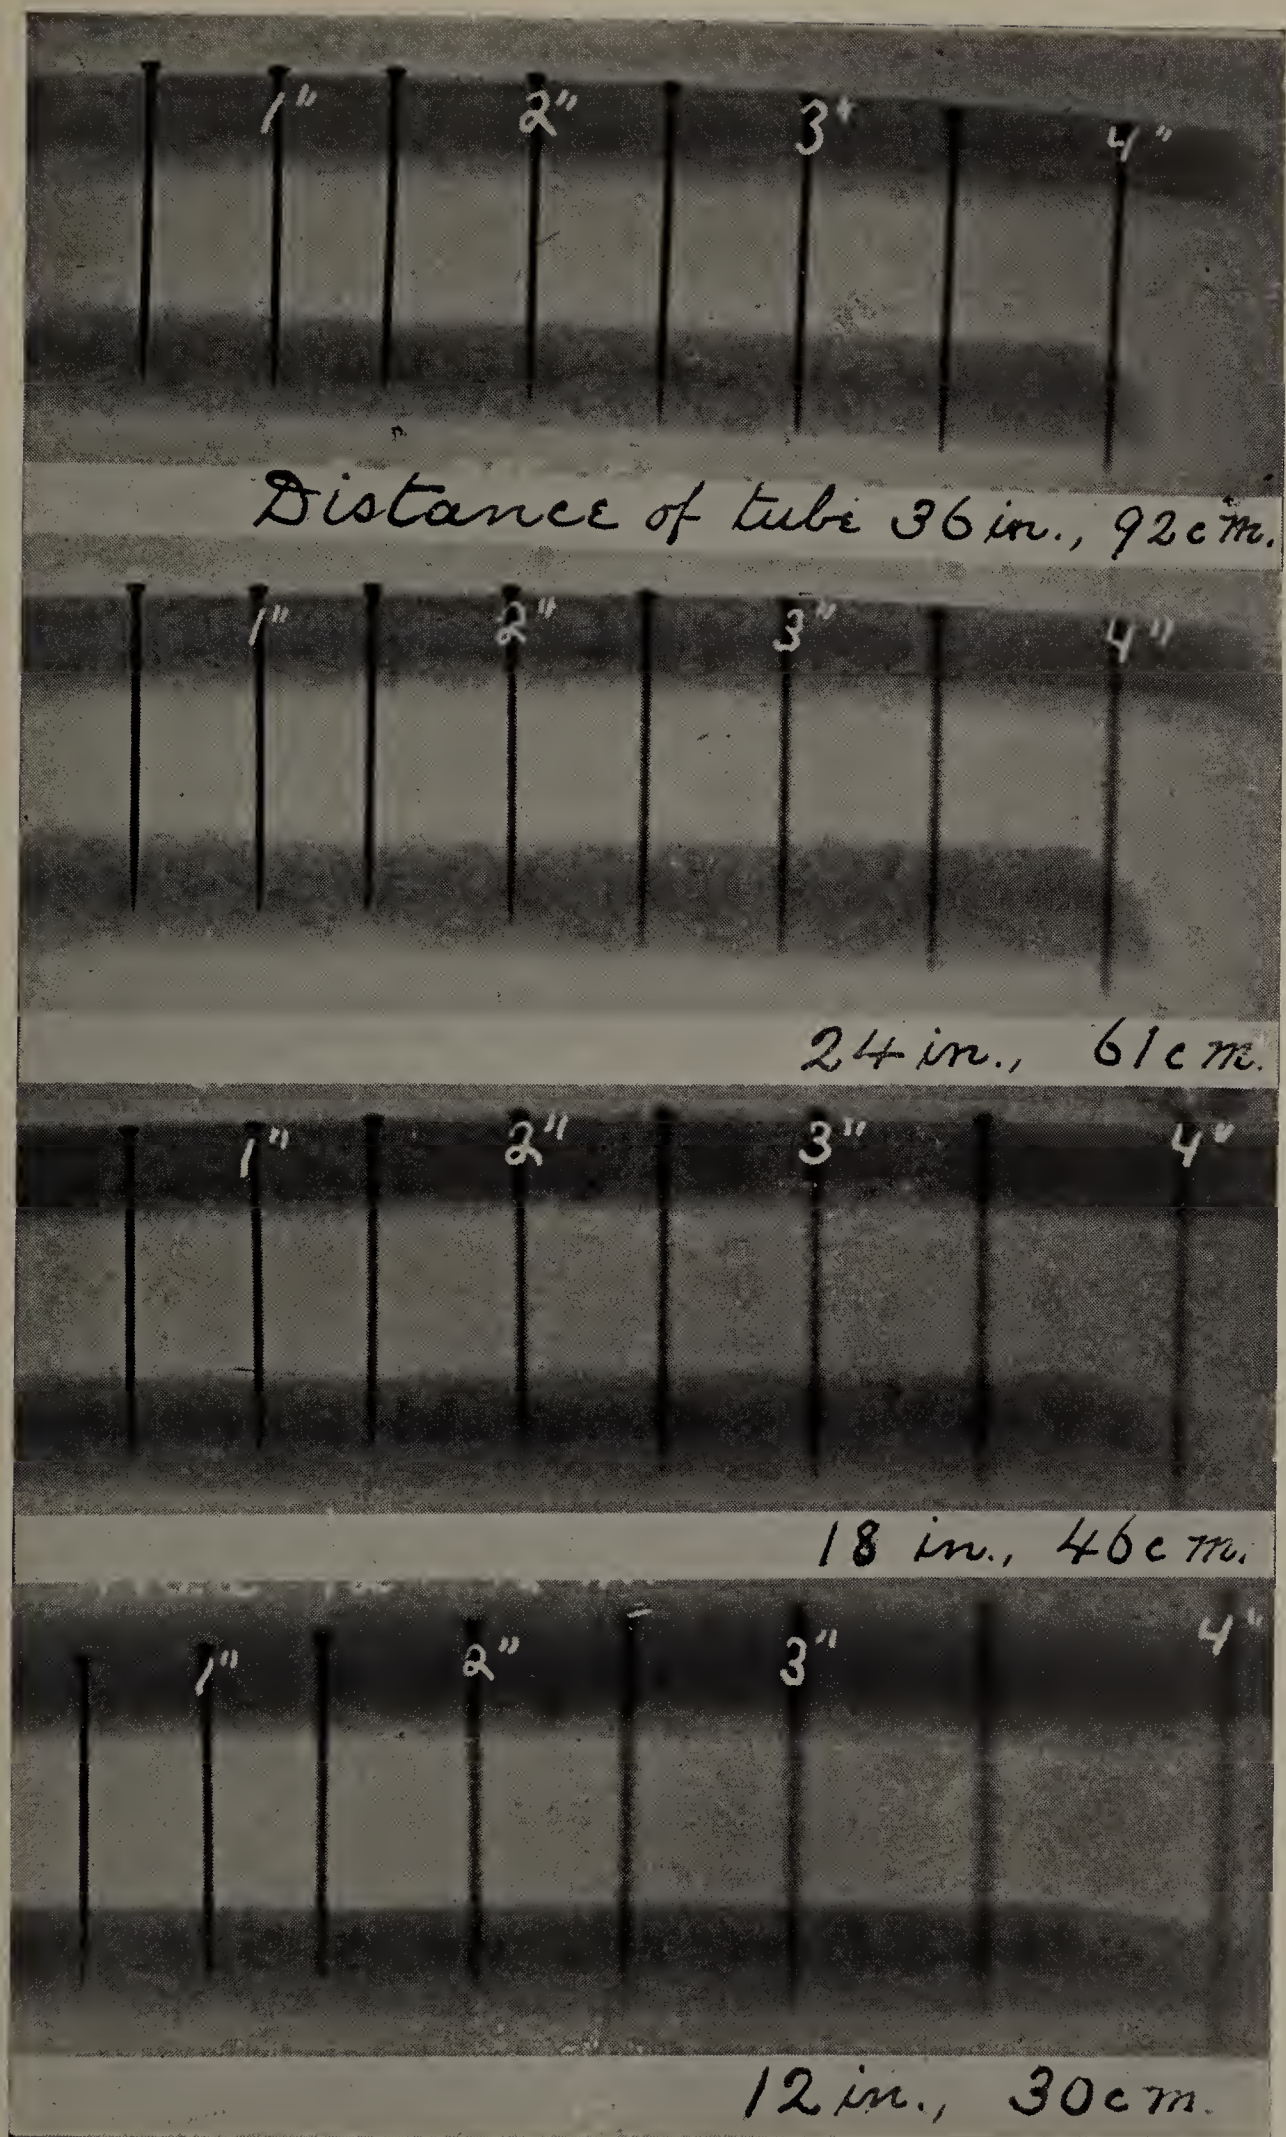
Full size of radiograph of pins inserted into cork at various distances from the vacuum tube and plate respectively. The figures in black give the distance of the plate from the tube; those in white, the distance of the pins from the plate (in inches).
